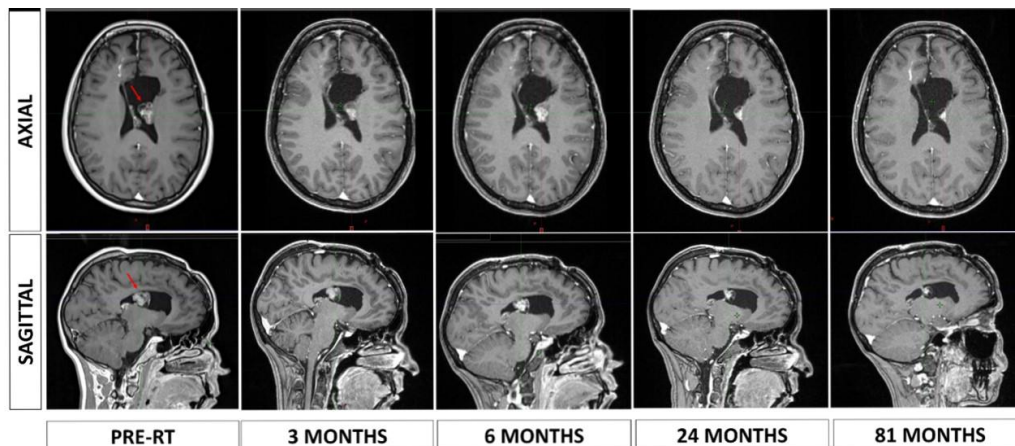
Axial and Sagittal MRI T1 sequence with gadolinium pre-treatment; At 3, 6, 9, 24, and 81 months after Cyberknife Radiosurgery. The red arrow points to the CN location.
